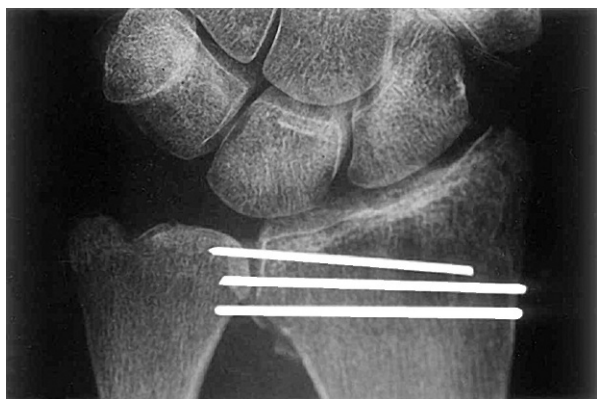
A postoperative radiograph with the Kirschner wires positioned in the radius. Reprinted with permission from Wallwork NA, Bain GI. Sigmoid notch osteoplasty for chronic volar instability of the distal radioulnar joint: a case report. *J Hand Surg.* 2001;26:454–459.
